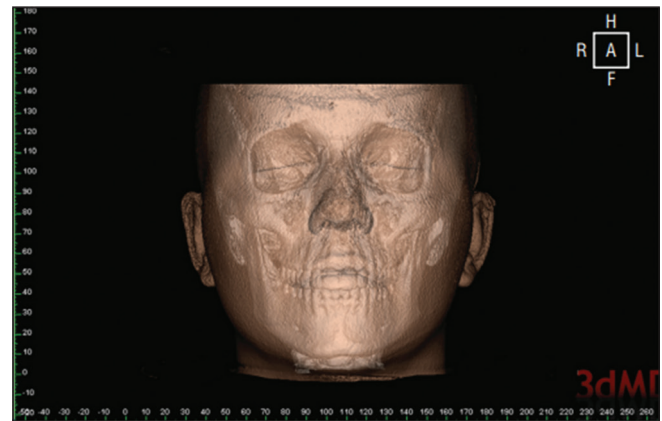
Superimposition of CBCT soft-tissue segmentation over hard tissue
